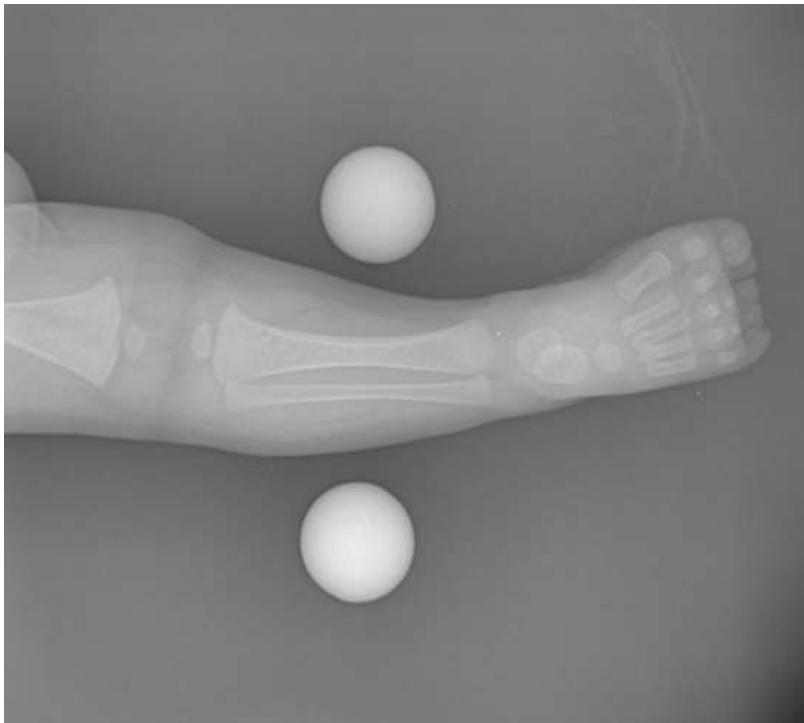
Setup for obtaining radiographs.
